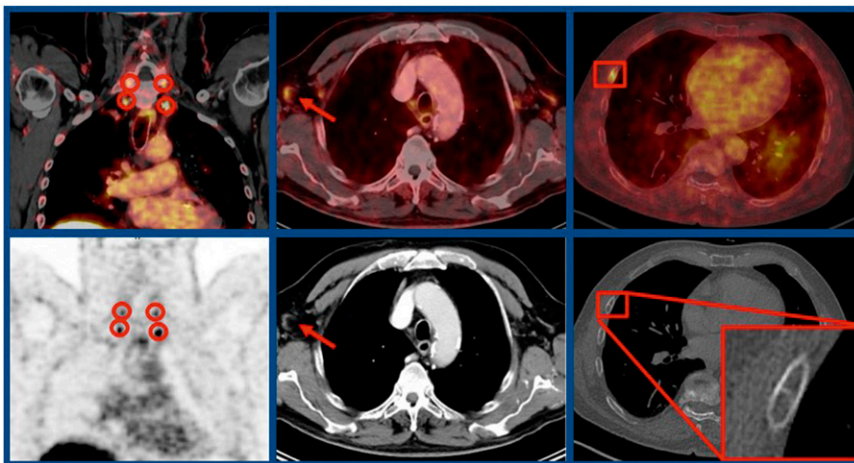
Comparative imaging with ^{18}F -rhPSMA-7 PET/CT and PET in cervical ganglia (left); ^{68}Ga -PSMA-11 PET/CT and CT in an unspecific axillary lymph node (middle); and ^{18}F -rhPSMA-7 PET/CT and PET CT in a fibro-osseous lesion (right) in patients with primary and biochemical recurrence of prostate cancer.
